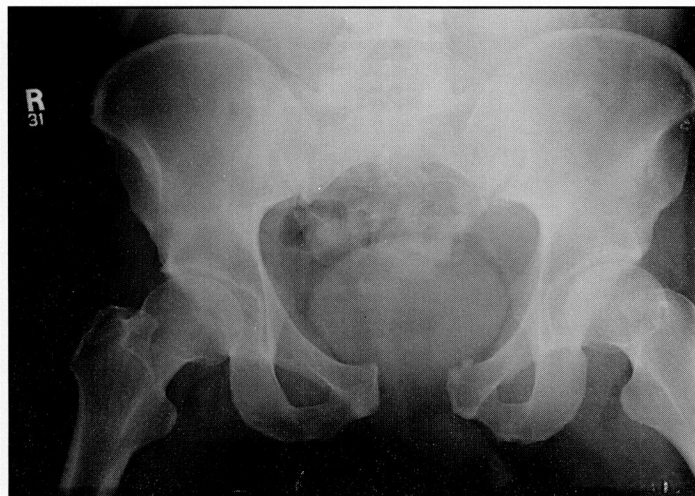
X-ray of pelvic fracture pre-application of TPOD® device.
